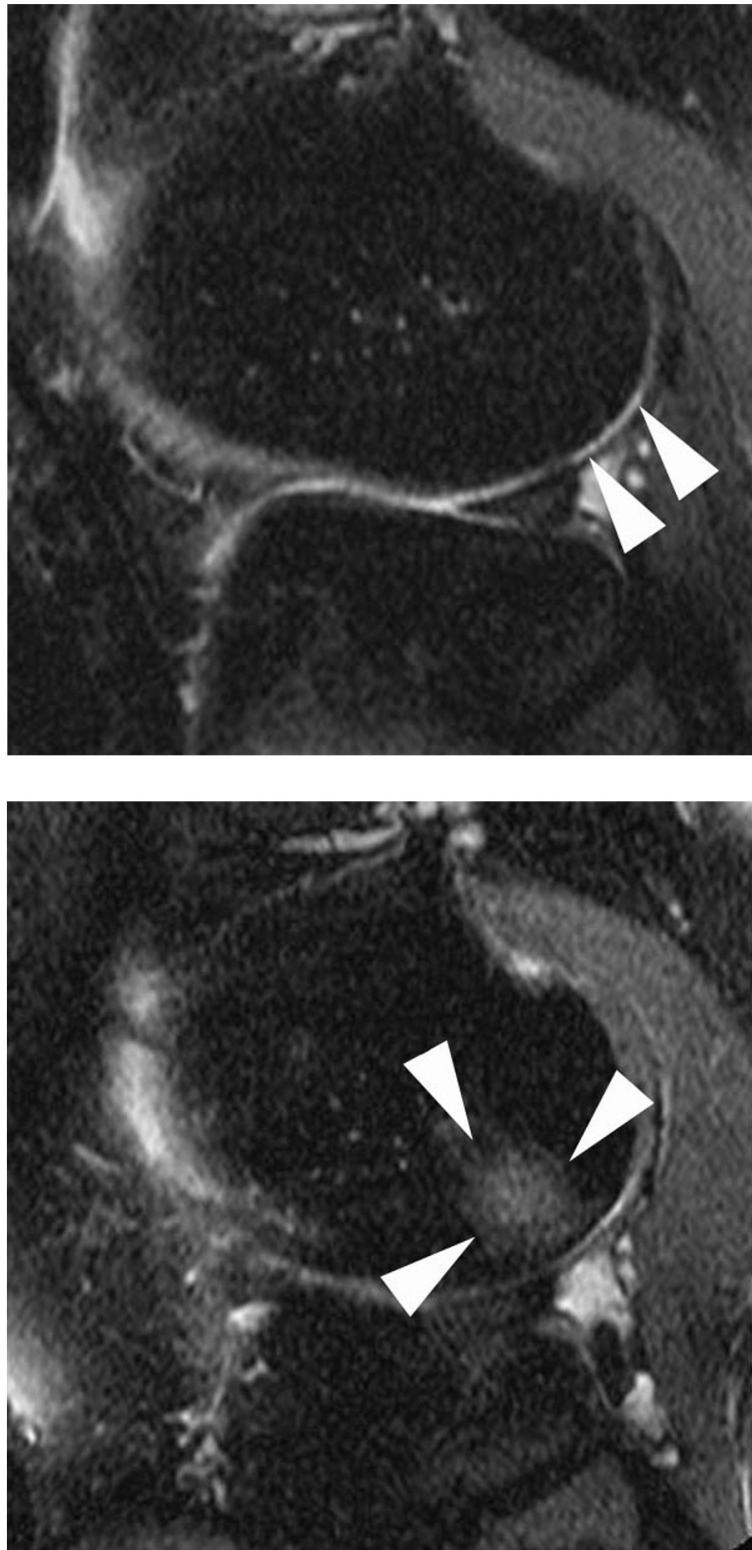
Incident BML. A) Sagittal fat-suppressed proton density-weighted MRI acquired at baseline shows cartilage thinning at the posterior subregion of the lateral femoral condyle
